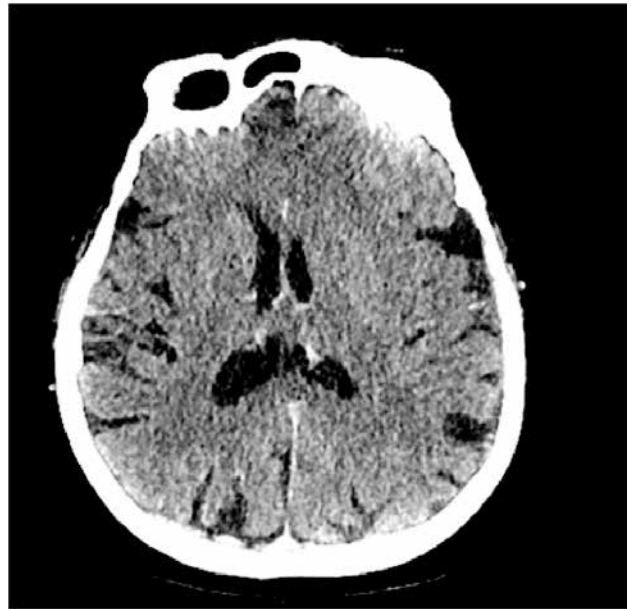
Multiphase CT scan for neuronavigation. Hypodense lesion in the left cerebral hemisphere involving the medial temporal region and adjacent left frontal lobe, without visible post-contrast enhancement. Mild sulcal effacement and slight asymmetry of the supratentorial ventricular system were noted, with mild narrowing of the anterior part of the left lateral ventricle. No intracranial hemorrhage was seen (09.12.2025)
